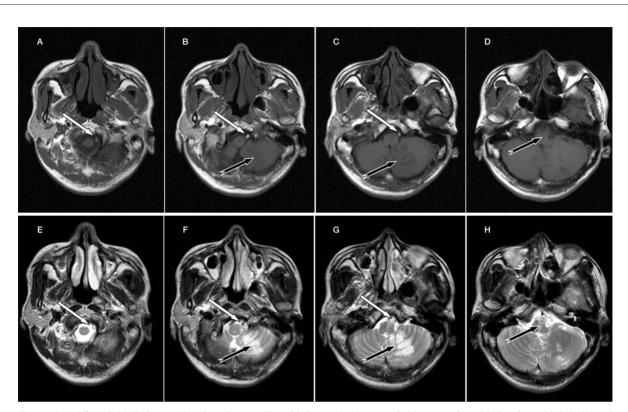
A-H) Axial MR image showing abnormality of left vertebral artery (white arrow) and infarction of left bulb and cerebellum (black arrow). A-D) T1-weighted MR image. E-H) T2-weighted MR image.
